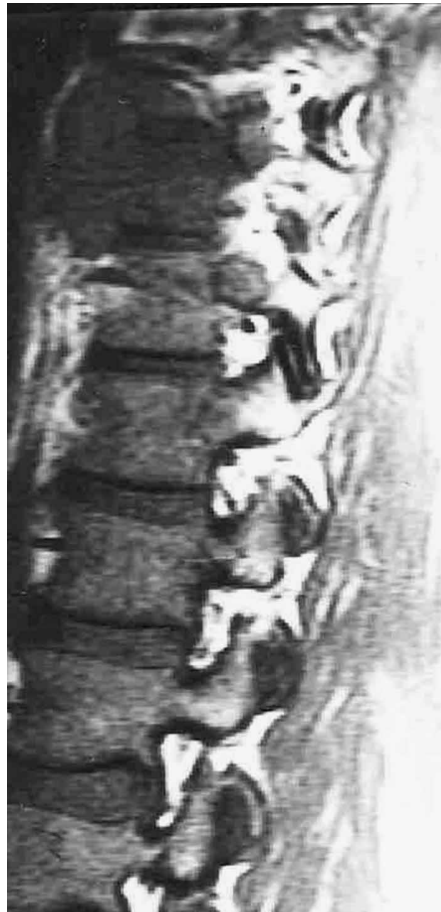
Sagittal T1-weighted MRI of the thoracic spine showing marrow infiltration, endplate destruction, and paravertebral mass at T5 and T6 level. Note involvement of anterior longitudinal ligament.
